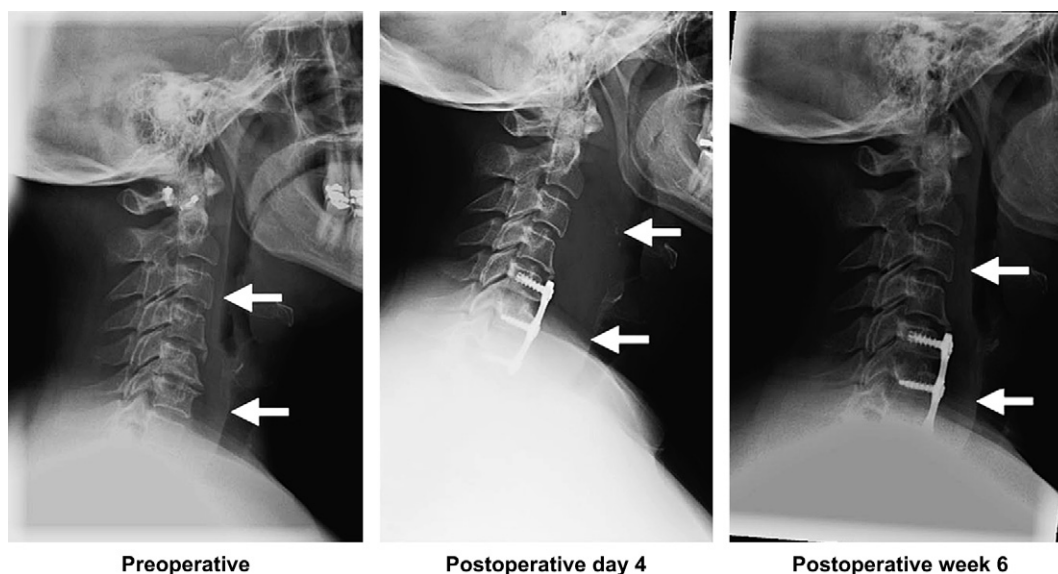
Postoperative lateral cervical spine radiographs of a patient who underwent C5–7 anterior cervical discectomy and fusion with recombinant BMP-2, allograft, and plate. Arrows demonstrate marked severe anterior neck swelling and dysphagia on postoperative Day 4, which decreased to baseline by postoperative Week 6 (reprinted with permission from Smucker et al. *Spine* 2006;31(24): 2813–2819).
